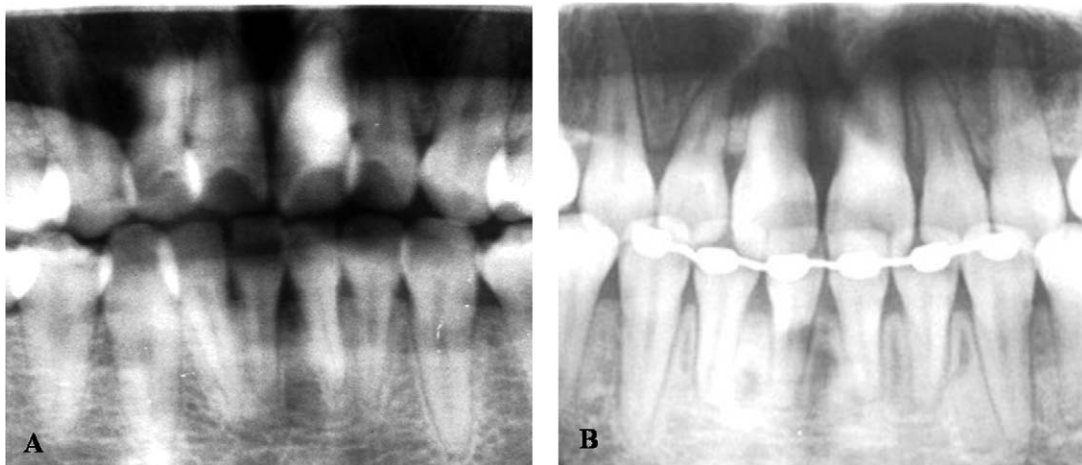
Panoramic radiograph at the pretreatment (A) and posttreatment (B) stages.
